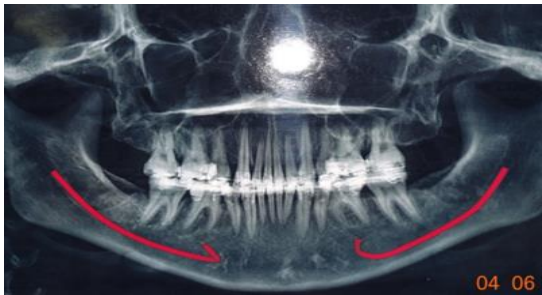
Preoperative orthopantomogram view.
